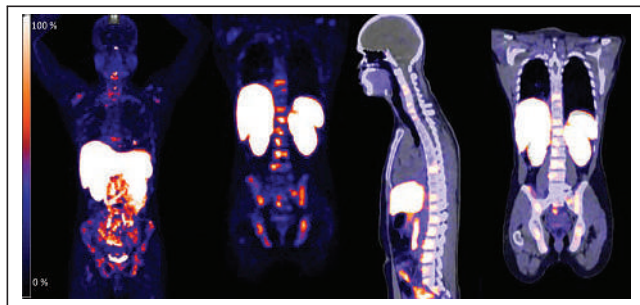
^{68}Ga -DOTATATE PET/CT scan. Diffuse bony metastasis is noted; uptake of ^{68}Ga -DOTATATE is less prominent than that of ^{18}F -fluoride in Figure 2. Liver and pleural involvement seen on subsequent ^{18}F -FDG scan 1 wk later is not clearly appreciated with ^{68}Ga -DOTATATE. From right to left maximum-intensity-projection PET, coronal PET, sagittal PET/CT, and coronal PET/CT images.
